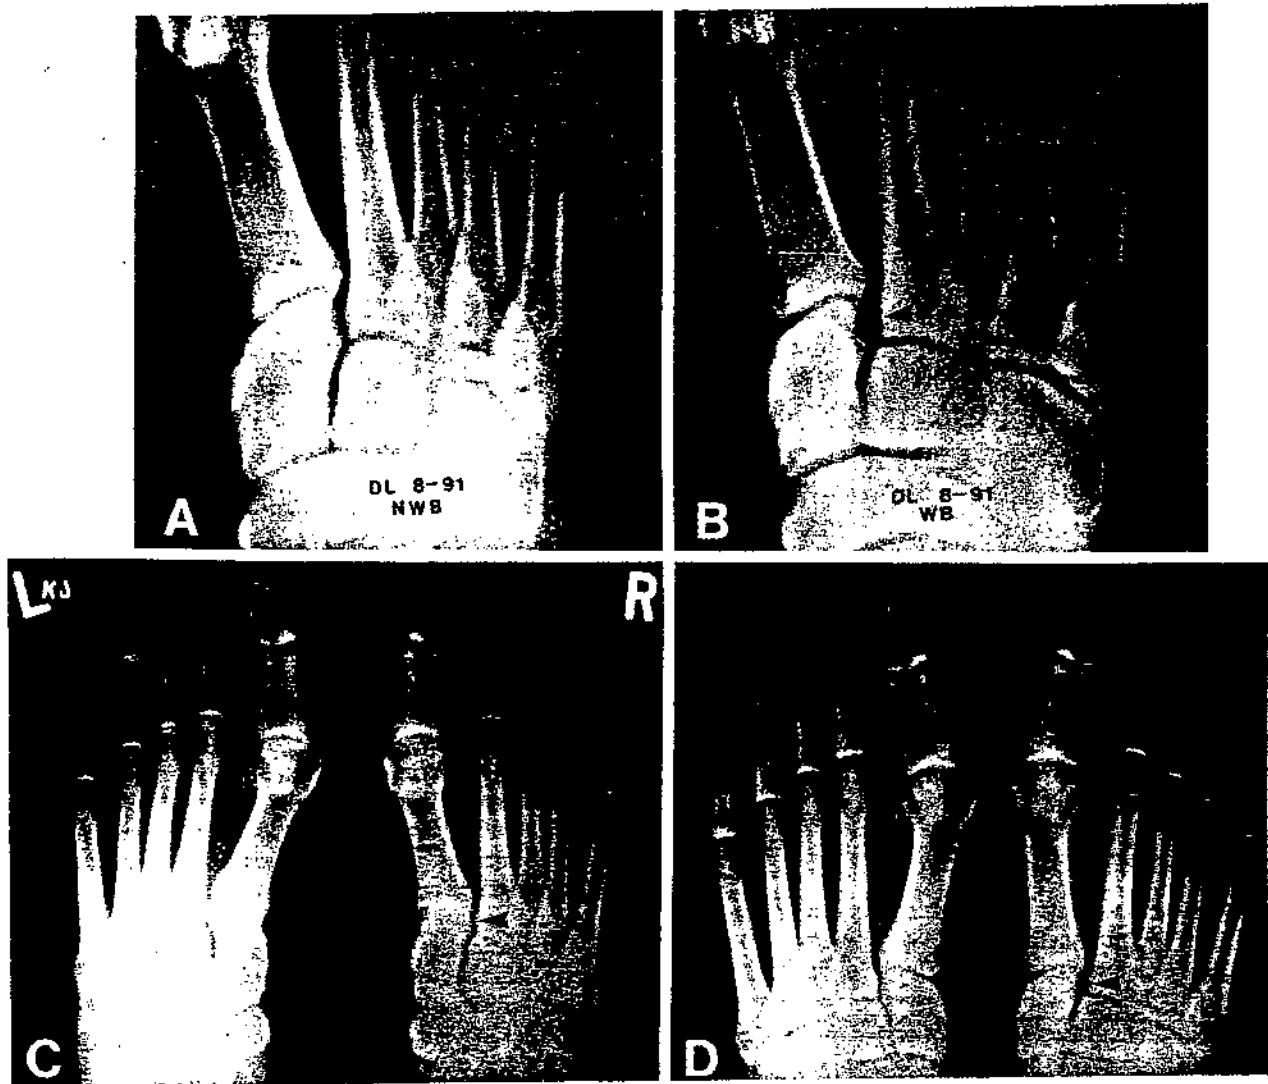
A 22-year-old football player with injury to his right foot. A, a standard, nonweightbearing AP radiograph was read as normal. B, a weightbearing radiograph of the same foot showing an increase in intermetatarsal distance from 1 to 3 mm. Without comparison views, diagnosis on the basis of this radiograph might still be difficult. C, a nonweightbearing AP radiograph of both feet showing a slight side-to-side difference. D, the diastasis was most evident on the weightbearing AP radiograph of both feet.
